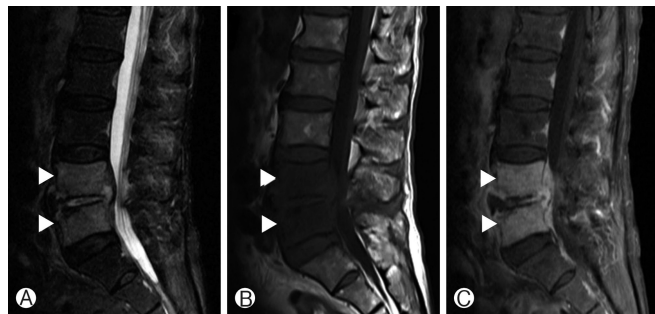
Magnetic resonance imaging of lumbar pyogenic vertebral osteomyelitis case. T2-weighted 1 sagittal image (A), T1-weighted 1 (T1W1) sagittal image (B), and T1WI sagittal image (C) with enhancement. Arrowheads indicate signal change of adjacent vertebrae.
